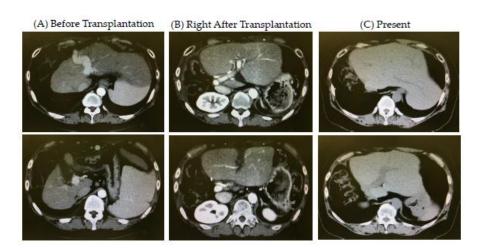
Computed tomography images before and after living-donor liver transplantation (LDLT): (A) before LDLT; (B) right after LDLT; and (C) present (about 8.5 years post-LDLT).
